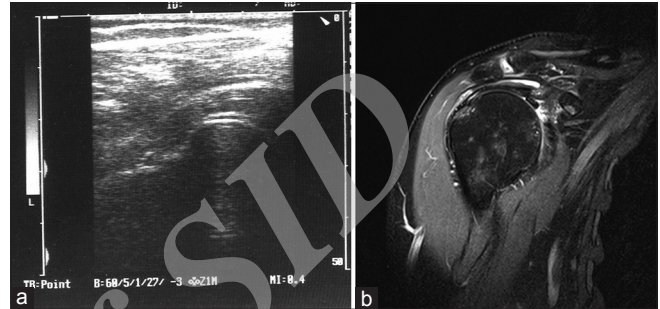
(a) Coronal ultrasound image showing hypoechoic defect of supraspinatus tendon and associated cartilage interface sign representing partial-thickness tear. (b) PD-weighted oblique coronal image showing hyperintense signal involving articular surface of supraspinatus tendon representing partial-thickness tear
